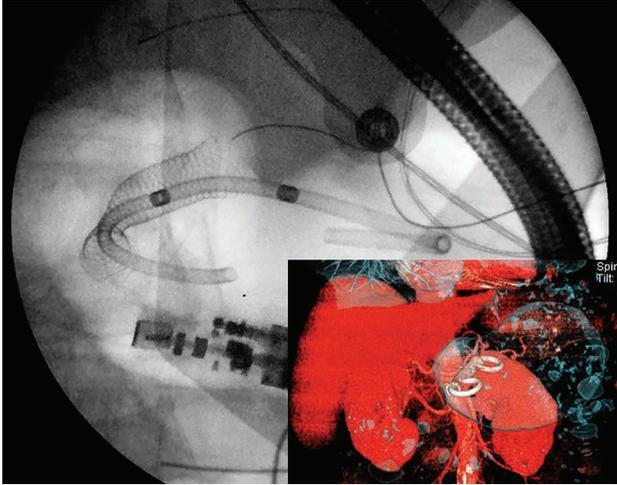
Fluoroscopic image obtained after success transgastric placement of the 10×60 mm FCSEMS, through which a 10 Fr×5 cm double-pigtail stent was deployed for anchoring purposes. Inset: Three-dimensional reconstruction of computed tomography images demonstrating FCSEMS bridging the gastric lumen and WOPN lumen, anchored by the double-pigtail stent within it
